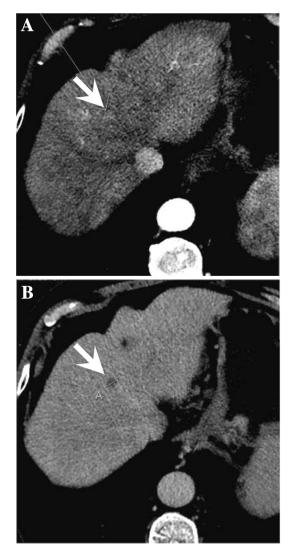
LR-5 (10-19 mm) with APHE and "washout". Contrast-enhanced CT in the arterial (A) and portal venous (B) phases show an observation (arrow) in the central portion of a cirrhotic liver measuring 12 mm exhibiting nonrim arterial phase hyper-enhancement (APHE), nonperipheral "washout", and no enhancing "capsule" or threshold growth. In v2018, the lesion is categorized LR-5.
